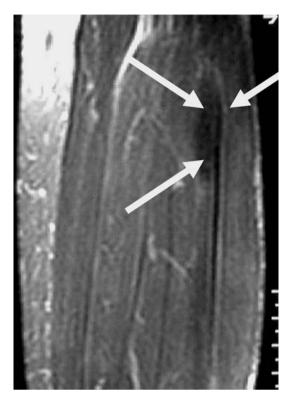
Coronal T<sub>2</sub>W MR image 3 months post surgery shows the diminished size of the lesion at the same level of the image of Fig. 3
